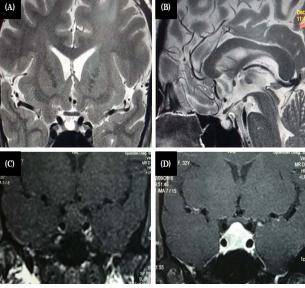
Upper panel: Partial empty sella in T2 weighted MRI
